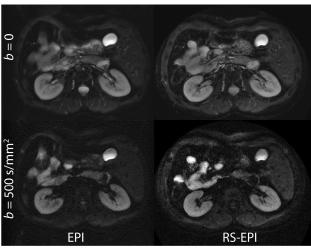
Comparison between ss-EPI and ss-RS-EPI DWI 30sec breath-hold images on a volunteer acquired at 3T. Imaging parameters were: FOV = 34cm, $\Delta z = 8$ mm, matrix-size = 192 x 192, TR = 2s, one b = 500s/mm² (S/I direction), TE_{min} = 72ms/56ms (EPI/RS-EPI), 7 blinds of width 64 (RS-EPI), and 7 NEX (EPI).
